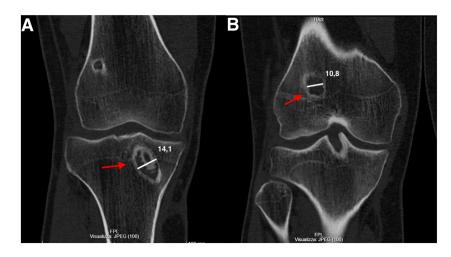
Anteroposterior coronal plane computed tomography scan of the right knee on presentation. (A) The previous tibial tunnel (red arrow) shows extensive osteolysis with a maximum tunnel diameter of 14.1 mm. (B) The previous femoral tunnel (red arrow) maximum width is 10.8 mm.
